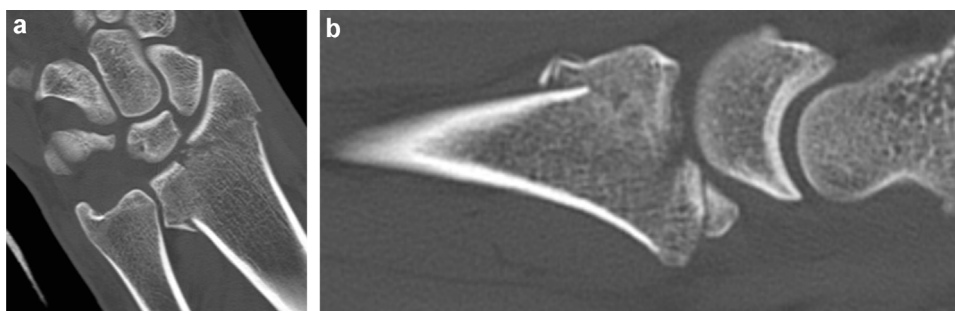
Preoperative CT scan. Frontal slice showing comminuted joint involvement (a). Sagittal slice through lunate showing comminuted and impacted intra-articular fracture. No damage to the volar metaphysis and epiphysis (b).
